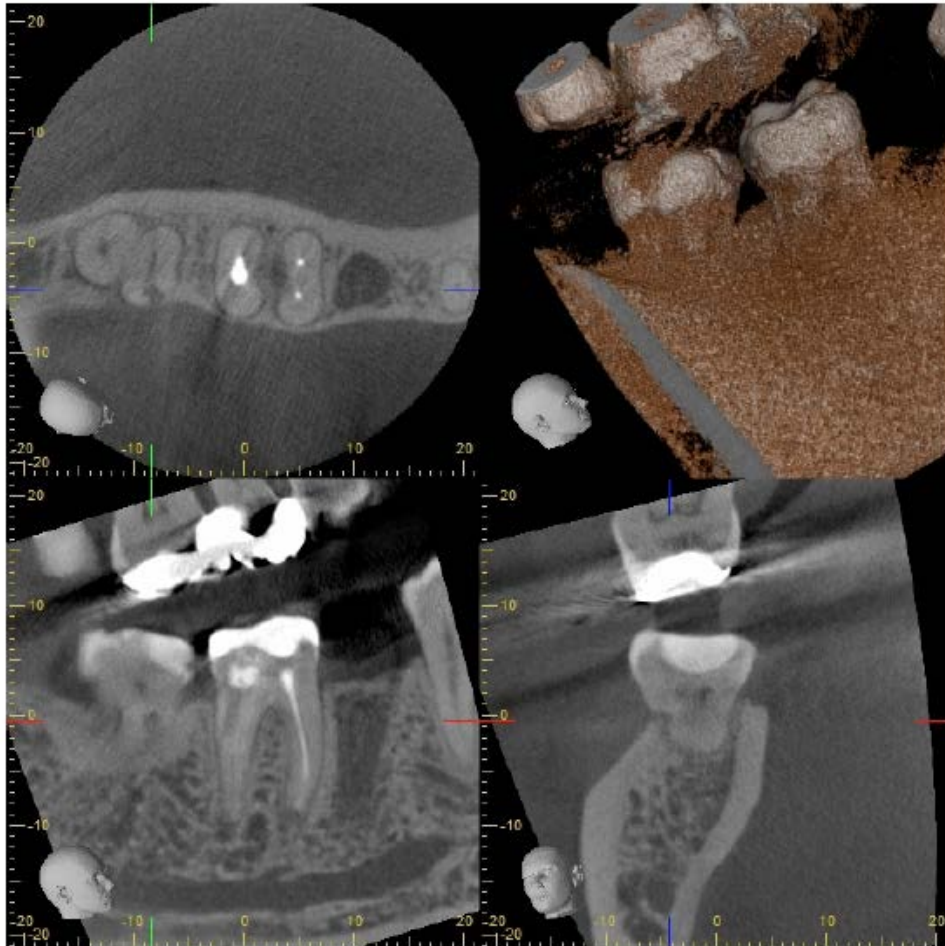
The CBCT imaging reveals an external resorption in tooth no. 47 to be the cause of the pain.
